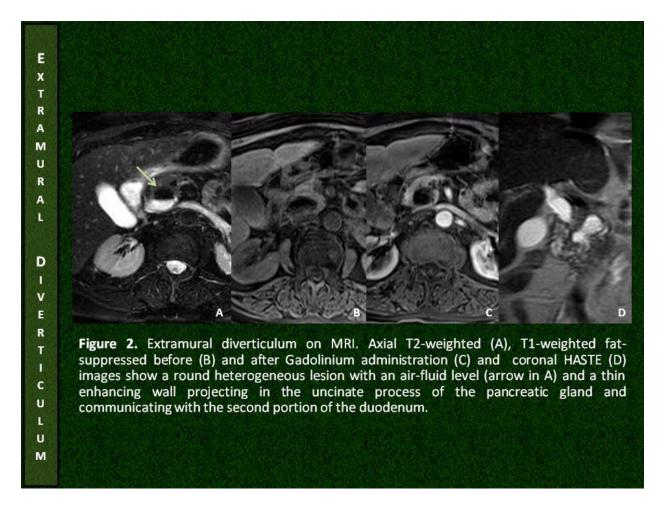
Extramural Diverticulum - MRI References: C. Ruivo; Coimbra, PORTUGAL
